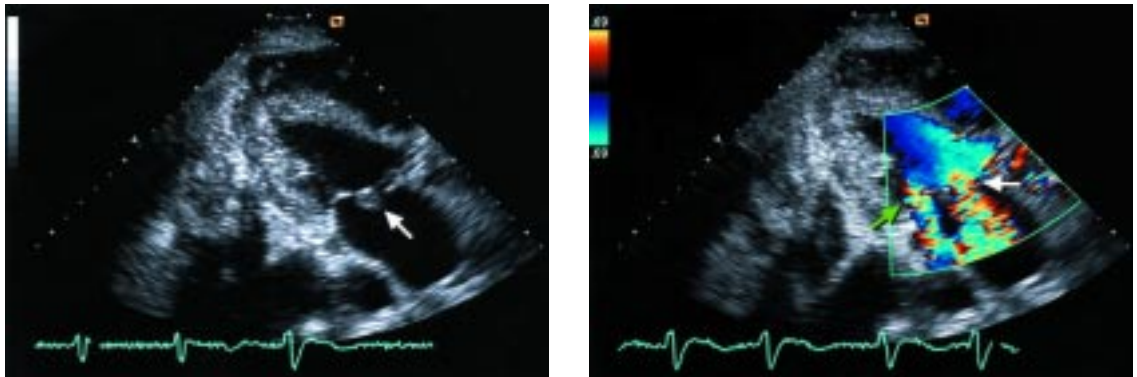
Left, surface echocardiogram showing mobile echodensity on the atrial surface of the anterior mitral valve leaflet (arrow); right, color Doppler echocardiogram showing two regurgitant jets through the mitral valve orifice (green arrow) and a perforated leaflet (white arrow).
